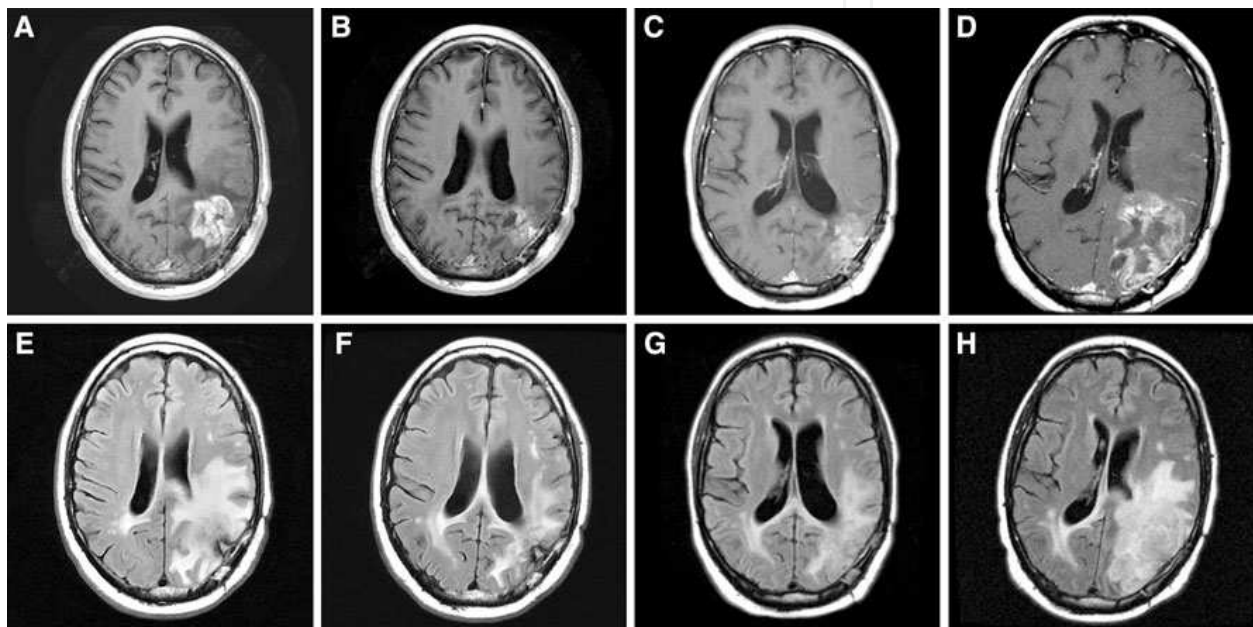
Rebound progression after discontinuation of bevacizumab: Original tumor area seen on post-Gd T1 weighted (a) and FLAIR MRI (e) sequences prior to initiating therapy with bevacizumab in a patient with recurrent high-grade glioma. Post-Gd T1 weighted (b) and FLAIR MRI (f) sequences that demonstrate partial response after 1 six-week cycle of treatment with bevacizumab. Post-Gd T1 weighted (c) and FLAIR MRI (g) sequences at the time of bevacizumab failure and subsequent cessation of bevacizumab therapy. Post-Gd T1 weighted (d) and FLAIR MRI (h) sequences at the time of “rebound” progression demonstrating a dramatic increase in area of enhancement and abnormal FLAIR signal 6 weeks after cessation of therapy with bevacizumab. [44]
